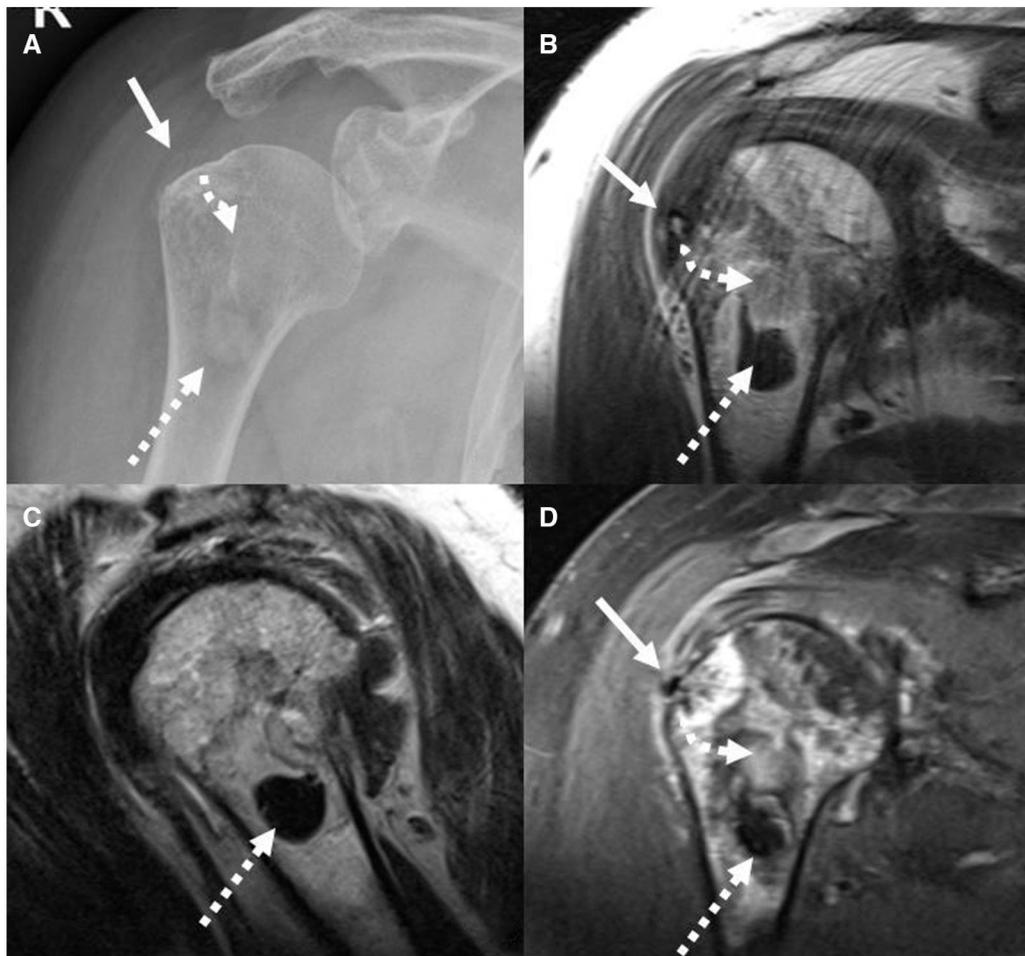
Conventional frontal radiograph of the shoulder (A) showing faint calcification in the region of supraspinatus tendon suggesting calcific tendinopathy (white arrow) and there is another well define focus of calcium within the proximal humerus (dashed arrow) suggesting intraosseous migration (curved dashed arrow). Corresponding coronal MRI T1W (B), sagittal T2W (C), and coronal fat-suppressed proton density (D) images showing supraspinatus calcific tendinopathy and confirms the presence of intraosseous calcium. The path of migration is well depicted (curved dashed arrow) with extensive reactive bone marrow oedema (D).
